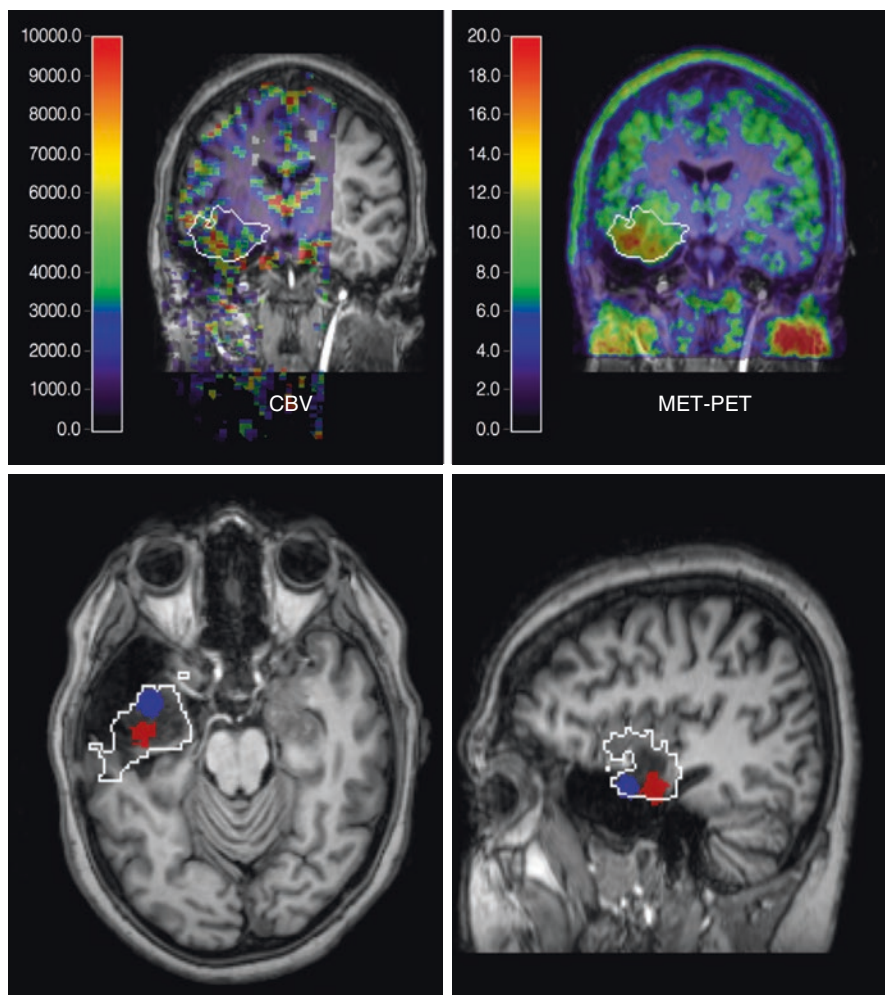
Low-grade glioma with focal increases of CBV (Dynamic susceptibility contrast-enhanced MRI) and amino acid uptake (MET PET) indicating beginning focal dedifferentiation. Images are shown in coregistration and fusion with T1-weighted contrast-enhanced MRI; the white outline indicates the extent of the lesion on FLAIR MRI. On the coronal cuts (top row), there is some correspondence between CBV and MET PET within the tumour, while the transaxial and sagittal slices (bottom row) demonstrate that peaks are actually not in the same position (peak MET uptake marked blue, peak CBV red)
